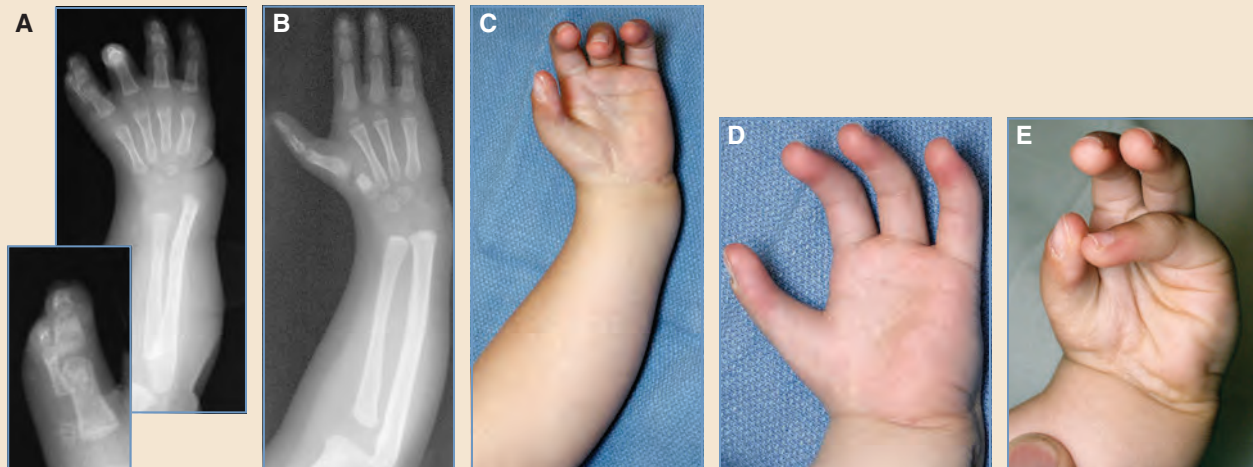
Stiff index digit and radial dysplasia. A, This 5-year-old boy, who was born with an absent thumb and partial absence of the radius, underwent a centralization at 8 months of age and release of an index PIP camptodactyly at 1 year of age. B and C, Six months later, a rotational-recession osteotomy of the stiff index ray was performed, and D, the growth of the metacarpal head arrested 5 years later. E, Although this thumb has limited motion and slight excess in length, a very functional pinch has been maintained. The appearance is good. A strong index–first dorsal interosseous muscle, now the thumb abductor pollicis brevis, has stabilized the palmar abduction. The radiograph demonstrates the characteristic persistent radial deviation despite a good centralization with broadening of the distal ulna, which now looks more like a radius than an ulna.
